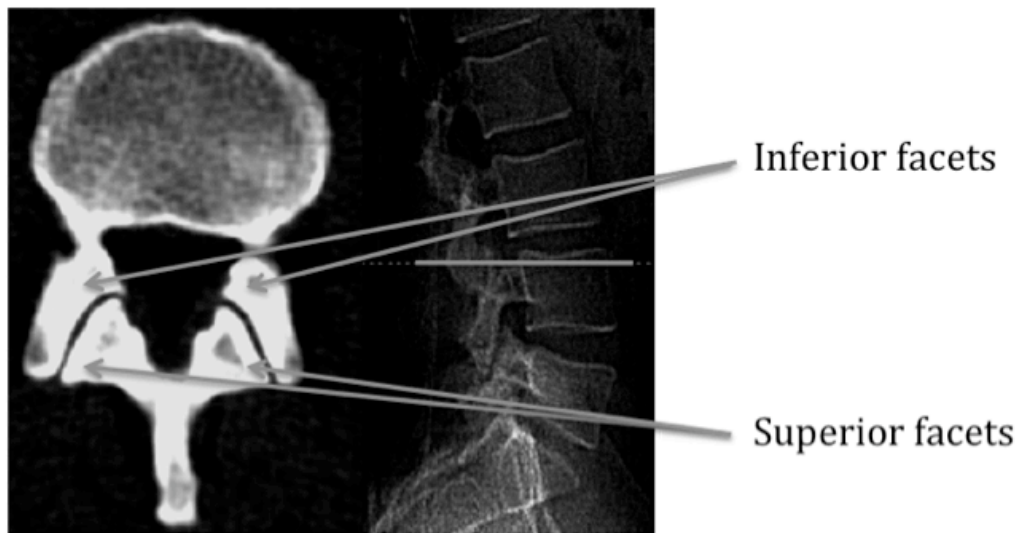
Transverse MRI slice through the L4 vertebra of the human lumbar spine. The image on the left shows the lateral and anterior facing orientation of the inferior facets from L3 and the medial and posterior facing orientation of the superior facets from L4. (Image taken from Kalichman and Hunter, 2007)
